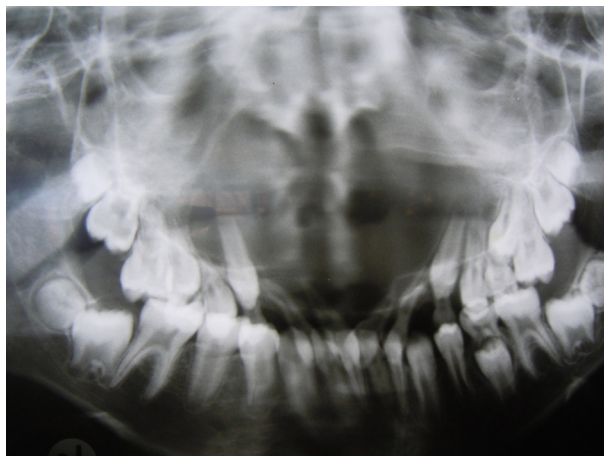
Panoramic view radiograph of a NPDC showing a massive osteolytic lesion extending horizontally from tooth 16 to tooth 26. Note the presence of mixed dentition and the grossly destroyed alveolar bone of the anterior segment.
